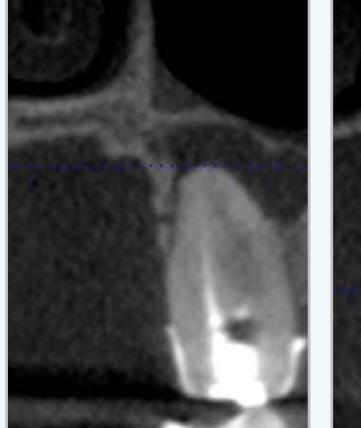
Pre-op CB-CT of hopeless teeth 26 and 27 with large apical lesions.
